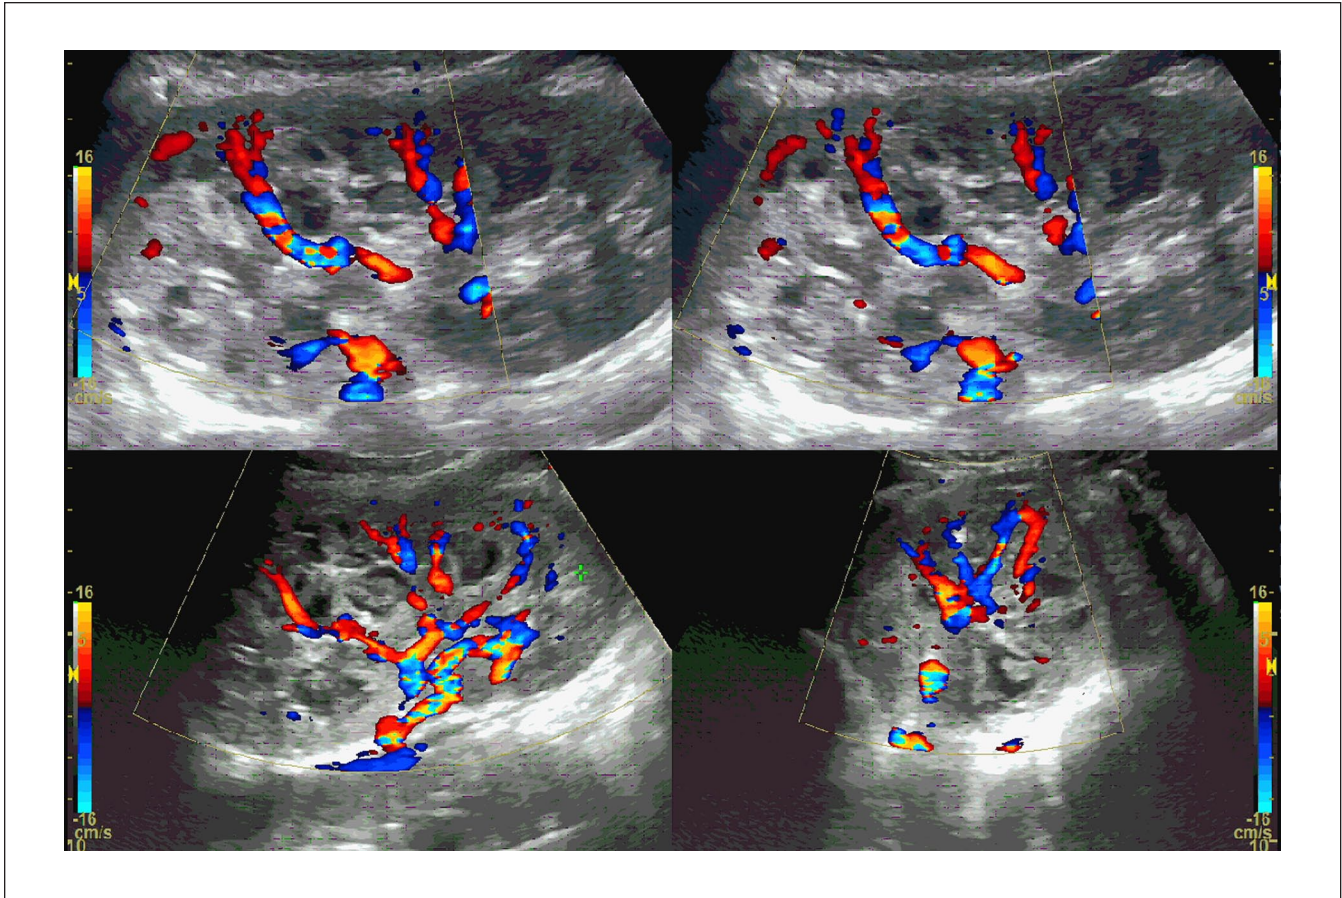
Ultrasound images of the right kidney demonstrated a heterogeneous hypoechoic renal parenchyma structure as a multicystic form accompanied by contusion of renal parenchyma at the superior pole. However, ultrasound is difficult to assess the initial URCD in the setting of trauma because the URCD image will mingle into hematoma contusion. Abbreviation: URCD, unilateral renal cystic disease.
